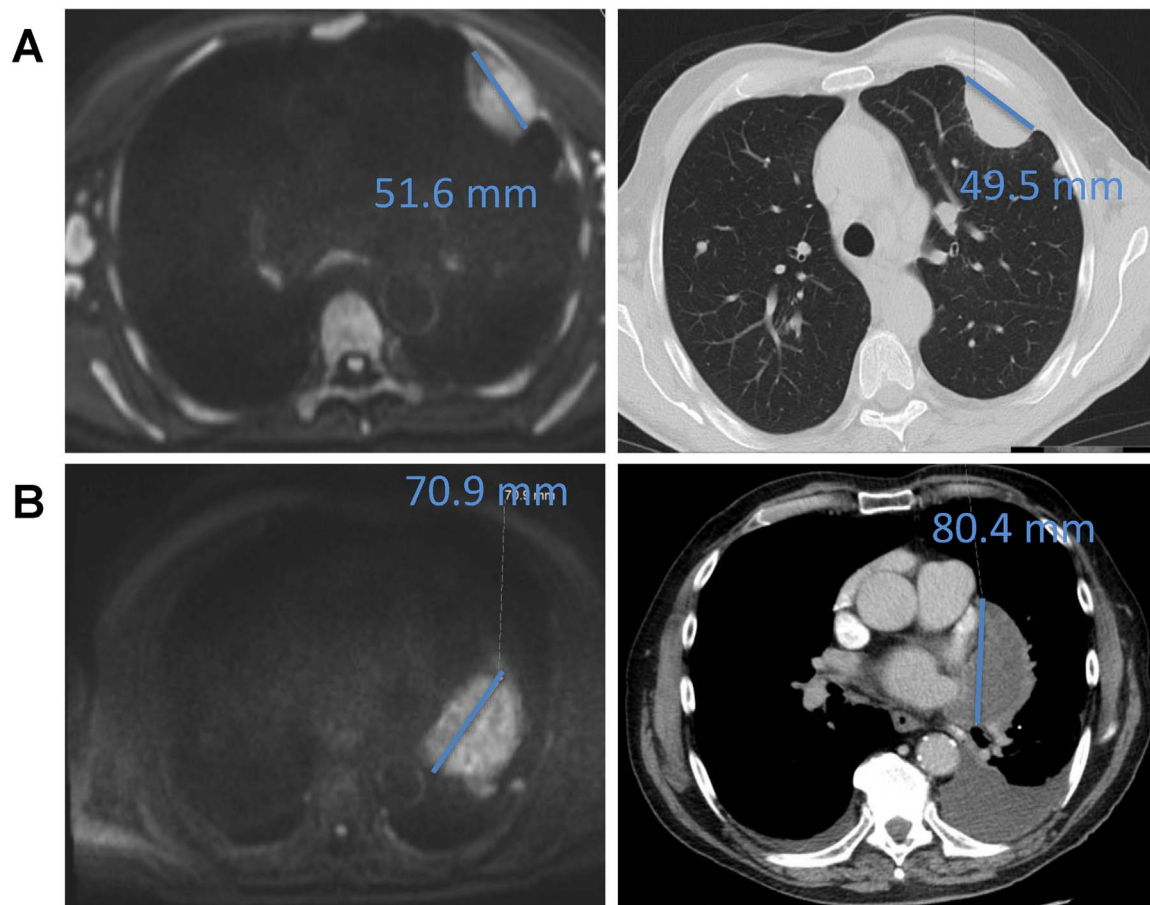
Two examples of different disparity between CT and DWI. A represents a pleural lesion pre-treatment and B a pulmonary lesion post-treatment.
